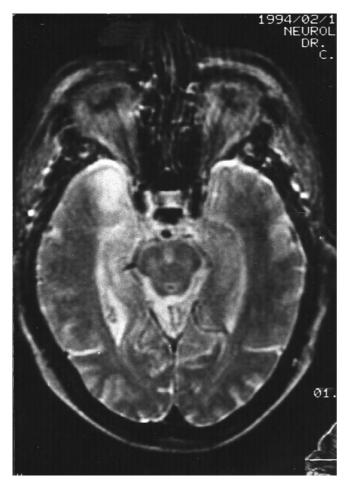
T_2 -weighted MRI showing high intensity signal in the medial and anterior right temporal lobe.
